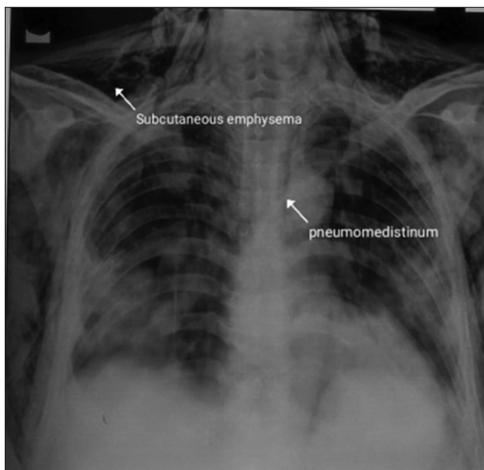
Chest X-ray posteroanterior view - white arrows showing subcutaneous emphysema (above) and pneumomediastinum (below)
